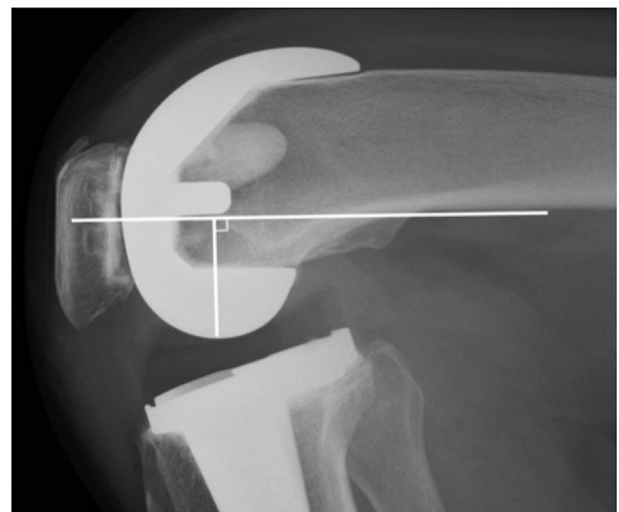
Preoperative and postoperative posterior condylar offset were evaluated from true lateral radiographs by measuring the maximum thickness of the posterior condyle.
